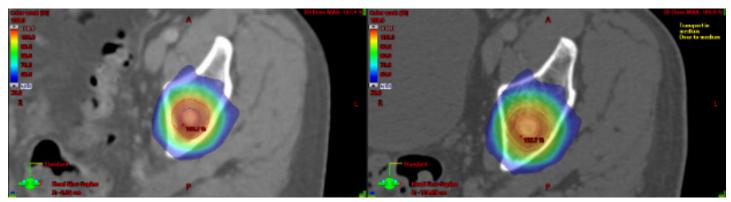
Adapted plan calculated using diagnostic CT and CBCT imaging (left) and calculated on the planning CT from the patient's actual treatment (right).
